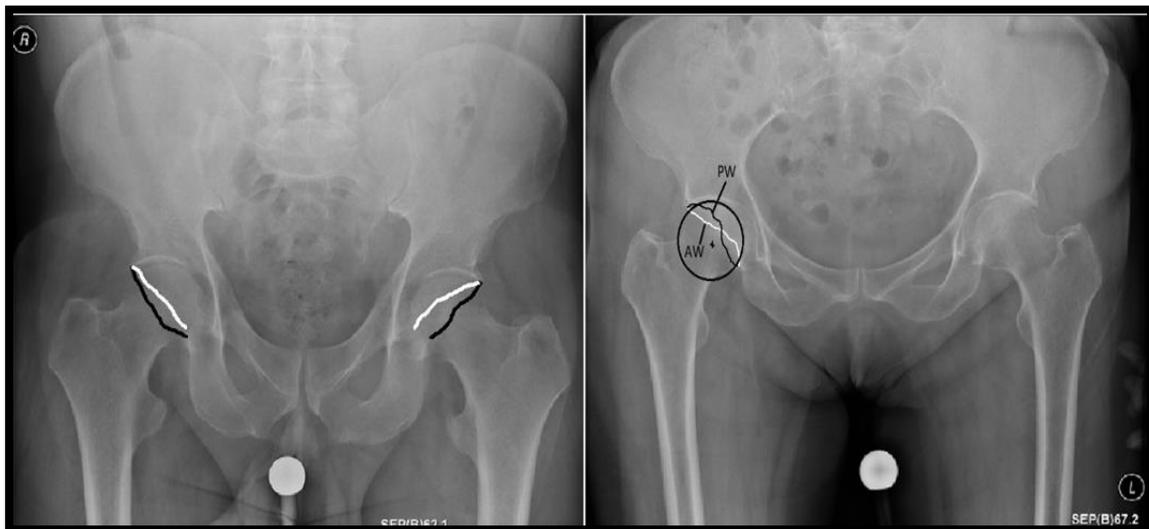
CT scan of the hip. The acetabulum opening in a normal anteverted position with the sagittal plane (A), the acetabulum in retroverted opening (B). The image adapted from (Reynolds et al., 1999).
